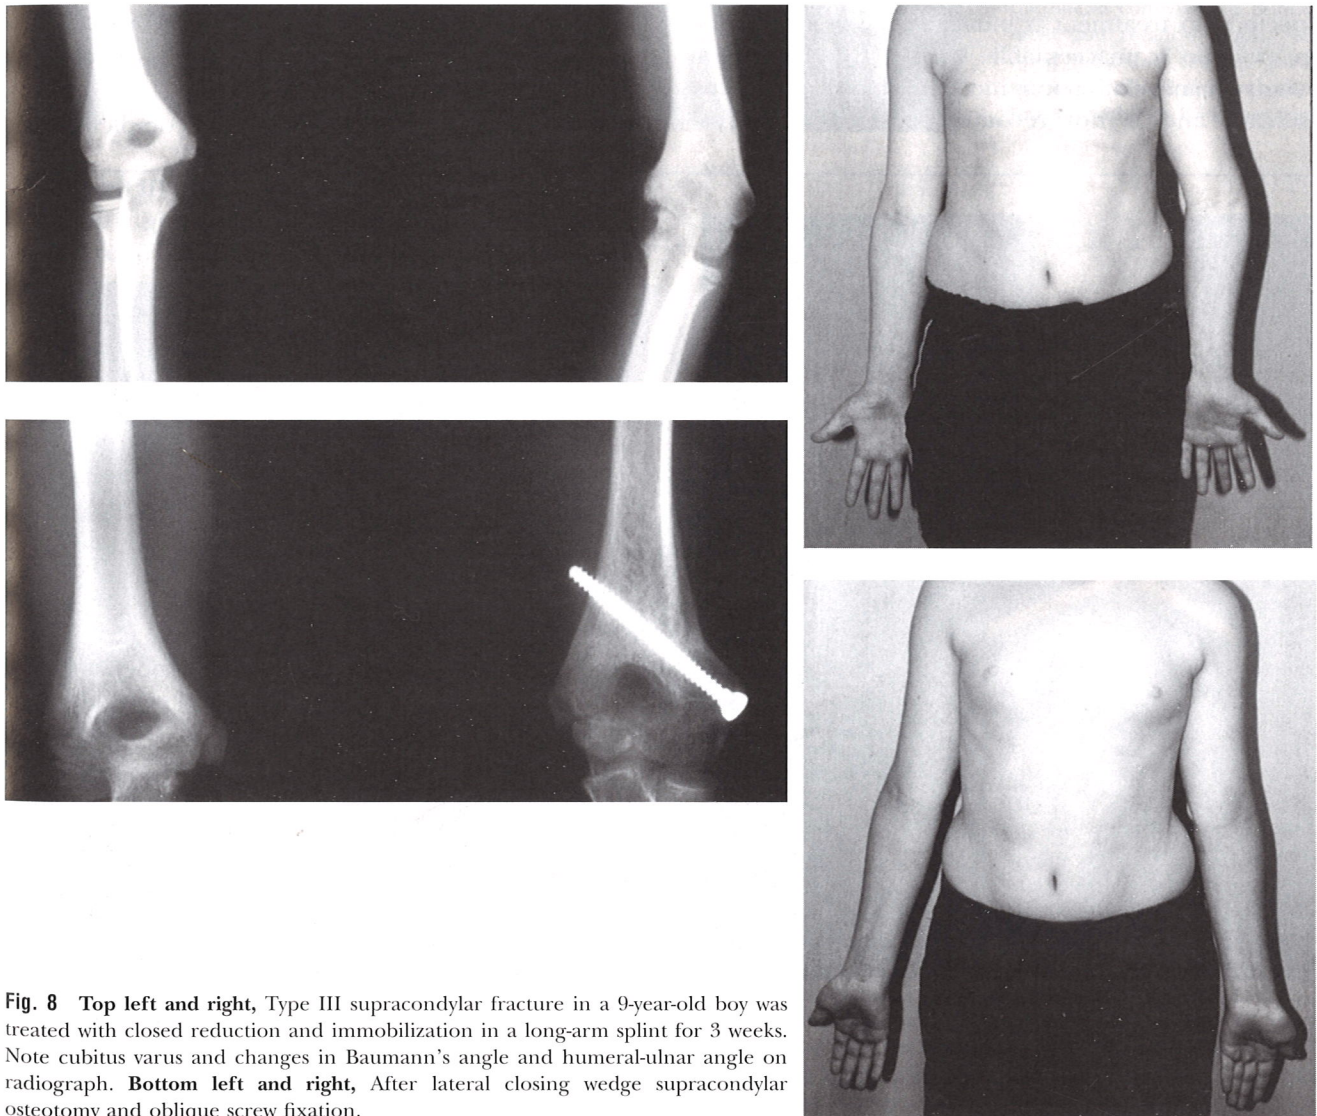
Top left and right, Type III supracondylar fracture in a 9-year-old boy was treated with closed reduction and immobilization in a long-arm splint for 3 weeks. Note cubitus varus and changes in Baumann's angle and humeral-ulnar angle on radiograph. Bottom left and right, After lateral closing wedge supracondylar osteotomy and oblique screw fixation.
